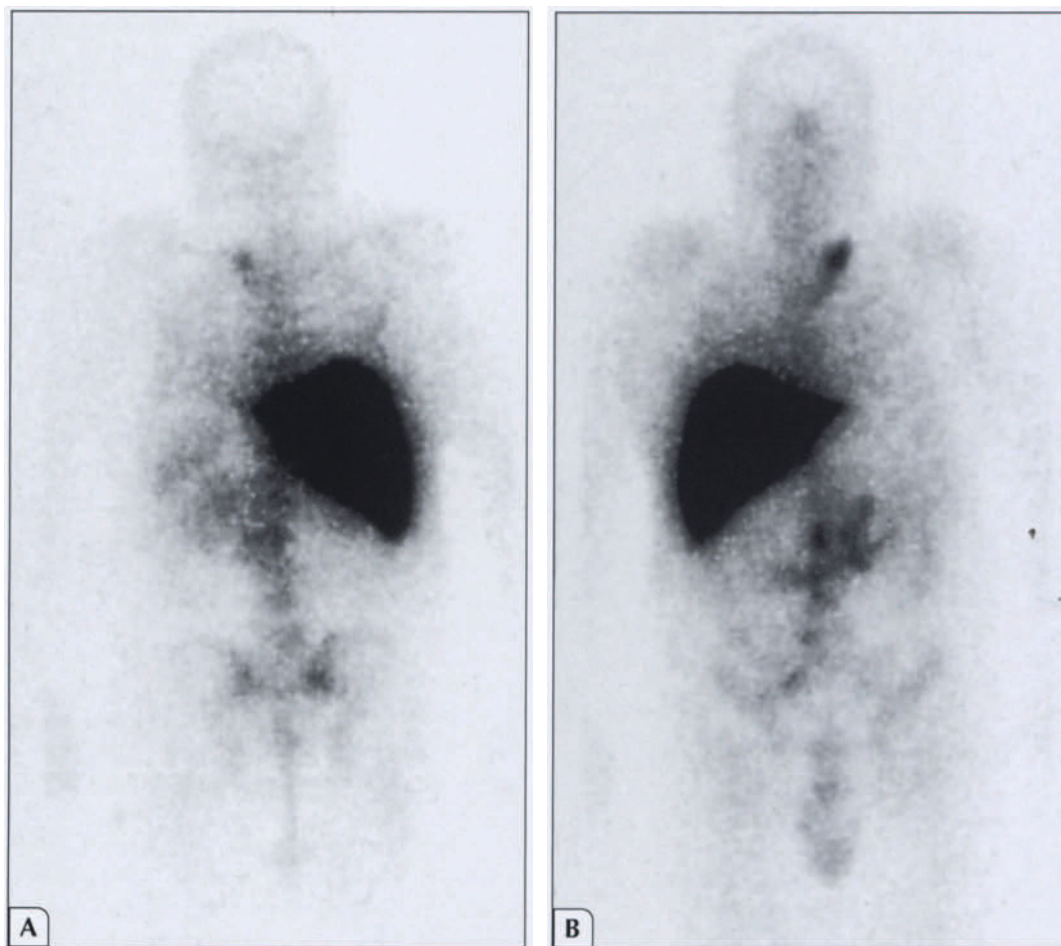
Immunoscintigraphy (ProstaScint; Cytogen Corp., Princeton, NJ). A, Immediate posterior day-1 scan. B, Delayed anterior day-4 scan. These ProctaScint images demonstrate abdominal soft tissue prostate cancer metastasis. ProctaScint recently was approved as a diagnostic imaging agent for patients with newly diagnosed, clinically localized prostate cancer who are at high risk for pelvic and abdominal lymph node metastases. This radiolabeled monoclonal antibody
